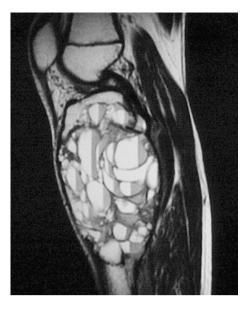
MR imaging of the proximal tibia shows high signal intensity in the proximal tibia, with multiple fluid levels. Erosion through the proximal tibial physis and extension into the epiphysis is clearly visible
